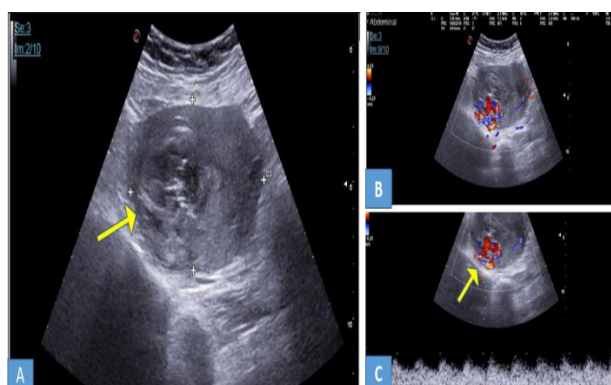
Ultra sound image of grey scale (A) mimicking retained products; and (B, C) colour Doppler shows AV malformation.
